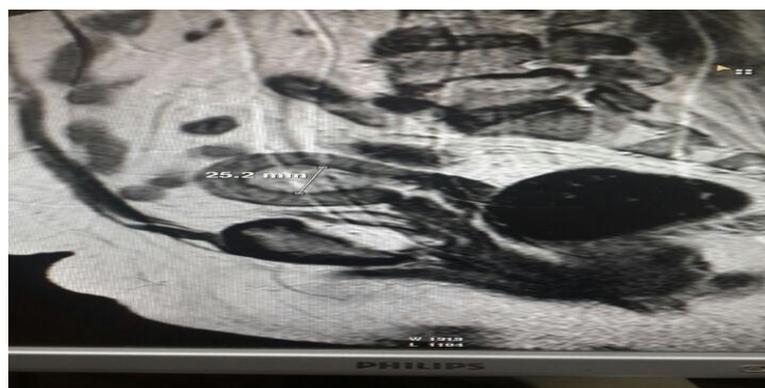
Sagittal view T2 MRI image for patient with increase endometrial thickness.
